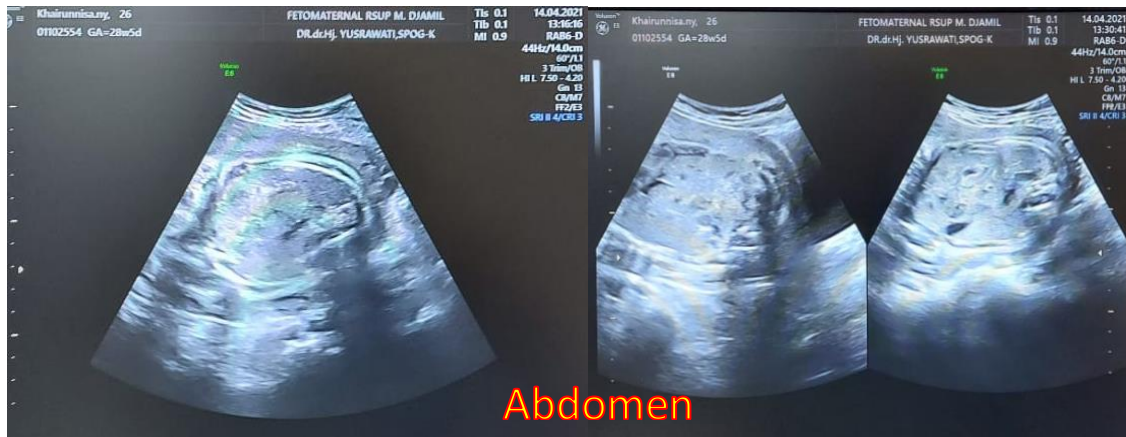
Ultrasound before amnioinfusion, SDP is difficult to assess, no kidney and bladder images are found (Black arrow: where the kidney should be, Red arrow: where the bladder should be)
